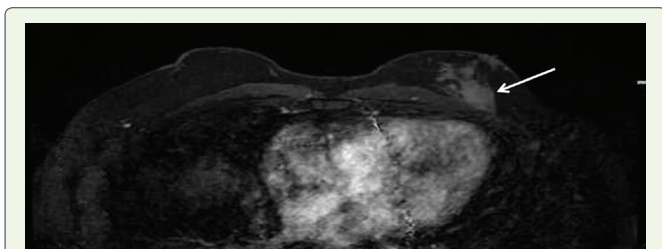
T1 Weighted MR image showing an irregular shape, spiculated margin, isointense mass in left breast in the posterior third region adjacent to the pectoral muscle.
